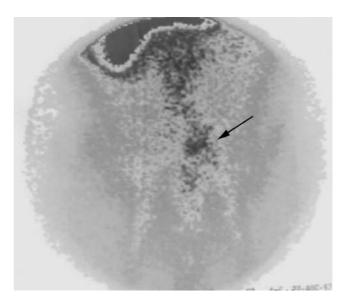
Immunoscintigraphy (ONCOSCINT) anterior view, revealed recurrence of the rectal adenocarcinoma.
